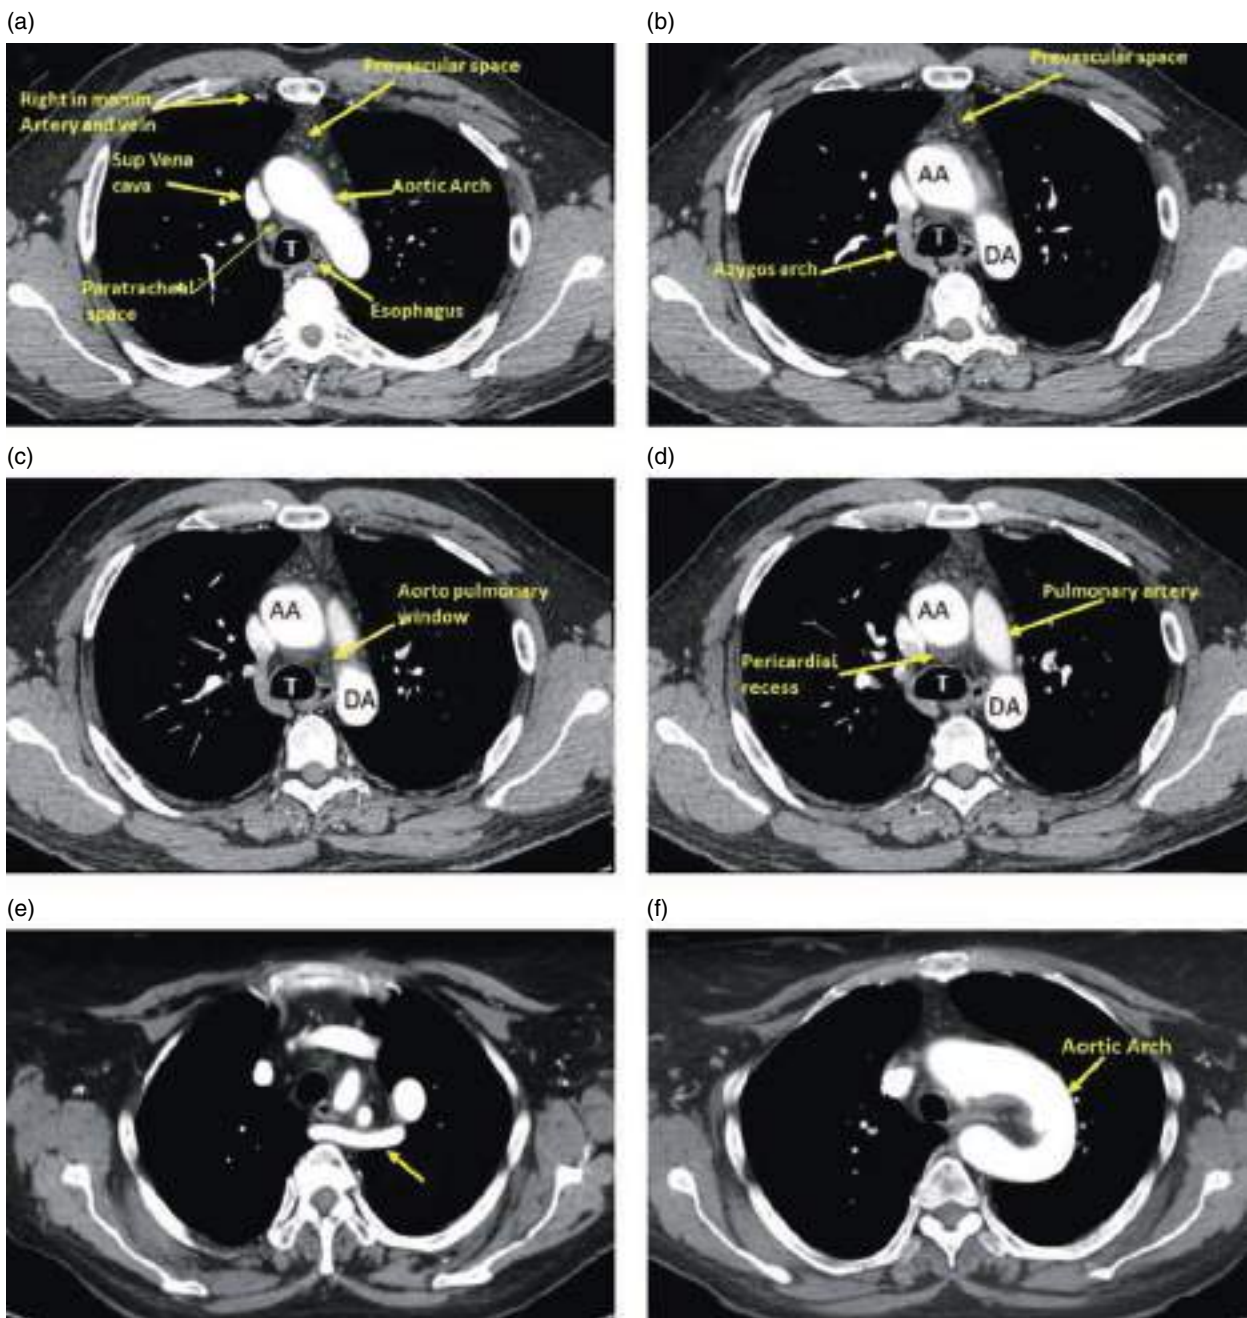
Sub-aortic mediastinum. Azygos arch and aorto-pulmonary window. (a–f). Axial contrast-enhanced CT images (mediastinal window). T, trachea; AA, ascending aorta; DA, descending aorta. Note the anatomical variant consisting of elongated left aortic arch with aberrant right subclavian artery (arrows in e and f).
